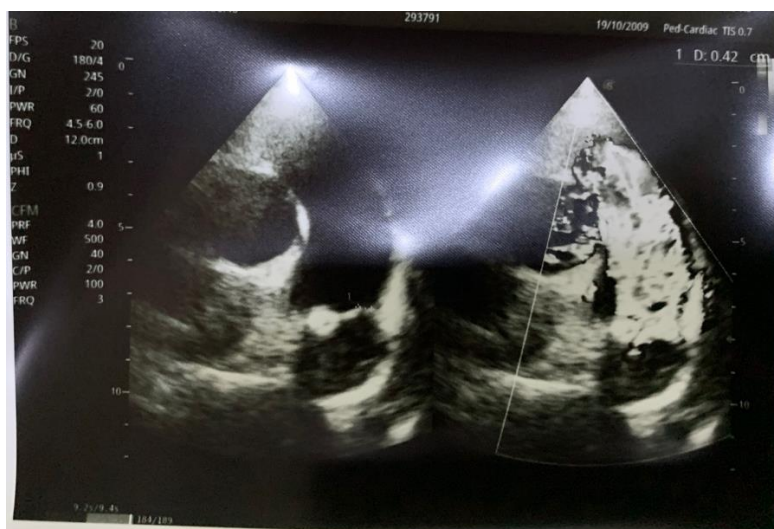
Follow-up echocardiography revealed a 4 mm patent ductus arteriosus (PDA) with hyperdynamic systolic function (EF 76%) and the absence of vegetation
